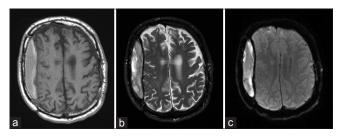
MRI of the brain without contrast on the day of admission. (a) TIWI showing hyperintense extraaxial fluid collection within the bounds of previous craniotomy on the right side. (b) T2WI showing hyperintense extraaxial fluid collection within the bounds of previous craniotomy on the right side. Both of these findings were consistent with late subacute SDH. (c) DWI shows some diffusion restriction within the extraaxial fluid collection on the right side. This was felt to be nonspecific secondary to history of previous extraaxial blood
